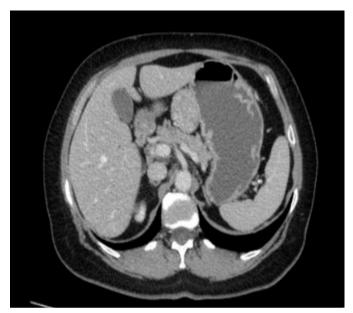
Axial view of computed tomography.
